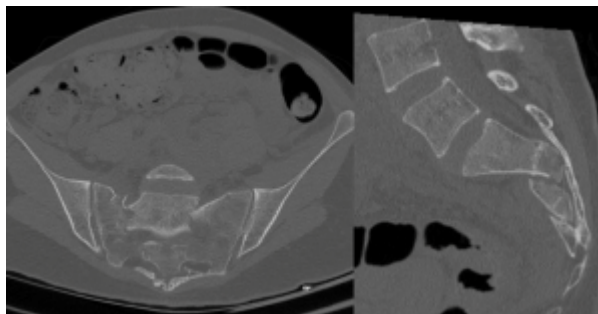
Sagittal CT reconstruction of bilateral sacral fracture with transverse component responsible for a spino-pelvic dissociation. Images Pr. Tonetti.
